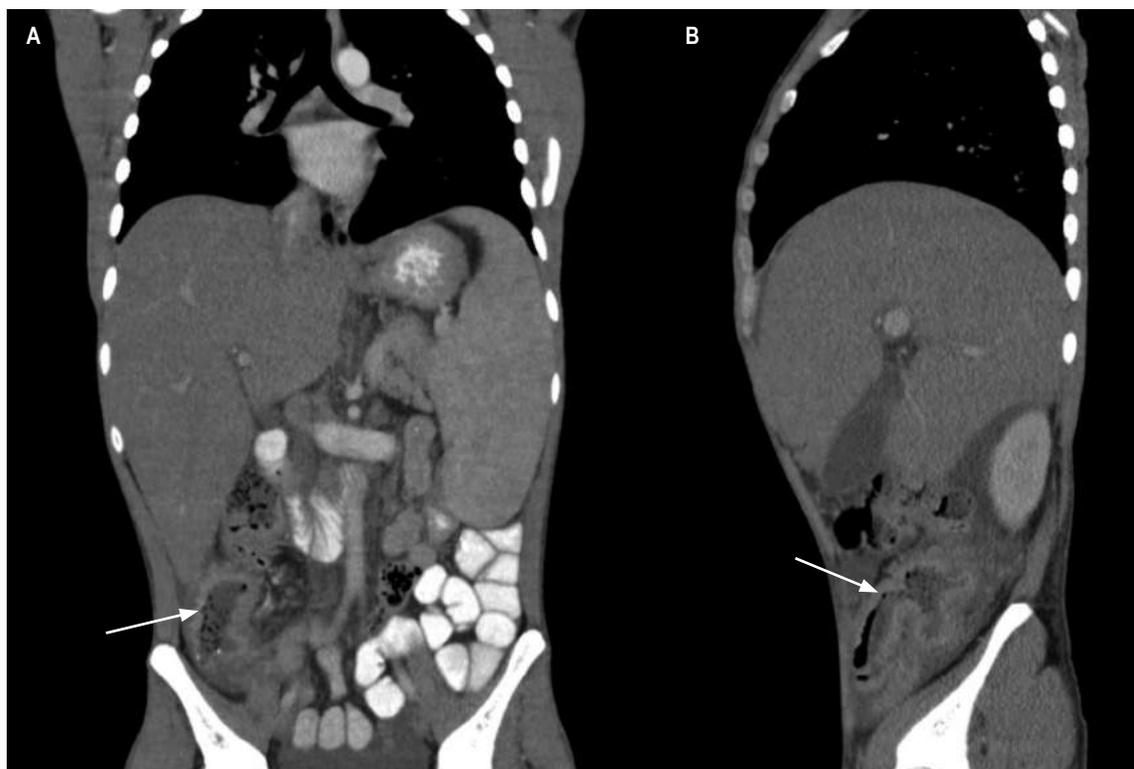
Contrast-enhanced coronal and sagittal computed tomography of the abdomen. A. Concentric thickening of the wall of the ascending colon with slight enhancement (arrow). B. Thickening of the distal ileum and ileocecal valve (arrow). Source: Patient's medical record.
